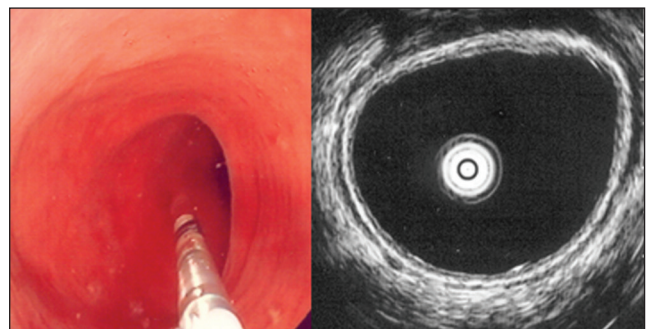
Colon lumen filled with water, miniprobe, and respective ultrasonographic image
